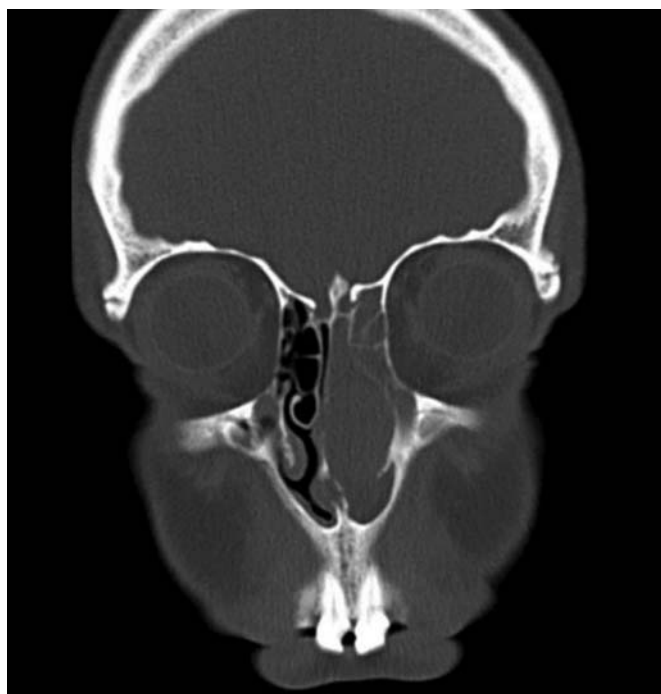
Coronal CT showing adenocarcinoma in the left nasal cavity.
